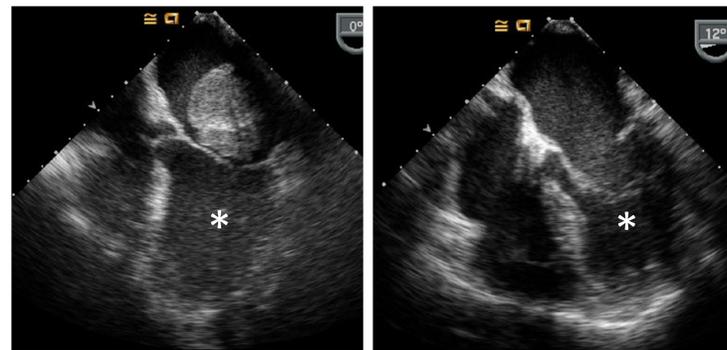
Transesophageal Echocardiogram Images
